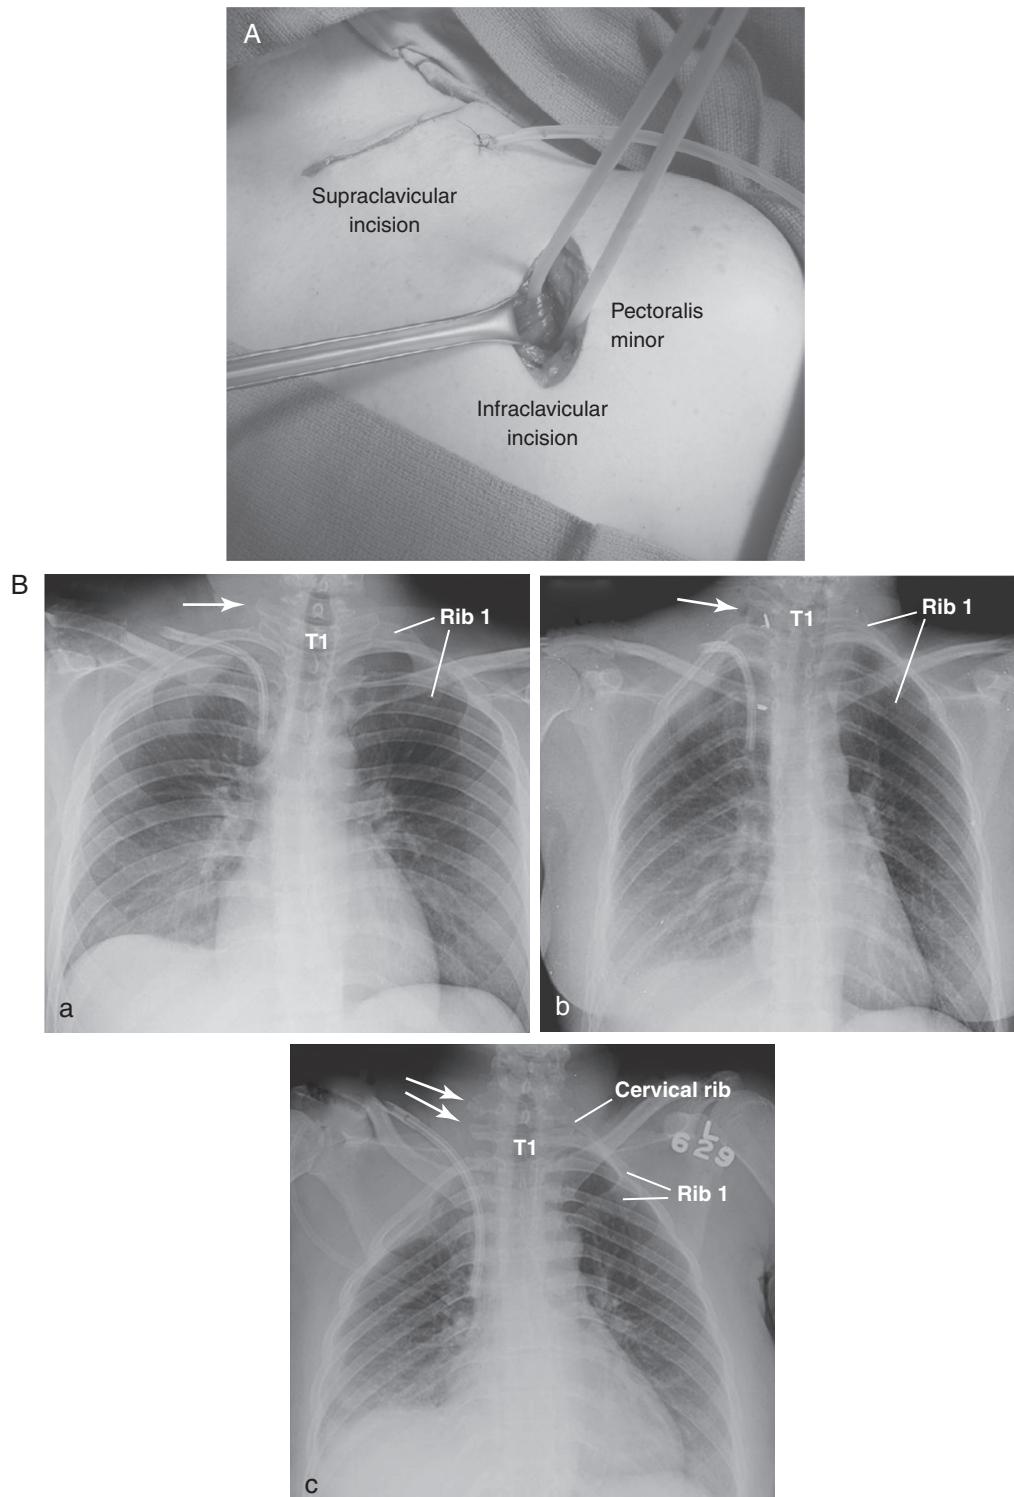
Pectoralis Minor Tenotomy and Postoperative Chest Radiographs. (A) Operative view of left lateral infraclavicular incision used to isolate the pectoralis minor muscle tendon, performed in conjunction with a supraclavicular thoracic outlet decompression procedure. (B) Postoperative chest radiographs. *a*, Chest radiograph after right supraclavicular decompression. The closed-suction drain is seen extending from the neck into the pleural apex, and the posterior end of the resected first rib is indicated (arrow). *b*, Chest radiograph after right supraclavicular decompression with an adjunctive cervical sympathectomy for reflex sympathetic dystrophy. The posterior end of the resected first rib is indicated (arrow), with the extent of sympathetic chain resection demonstrated by the position of radiodense clips at the first and fourth thoracic levels. *c*, Chest radiograph after right supraclavicular decompression with resection of the cervical and first ribs. The posterior ends of the resected cervical and first ribs are indicated (arrows).
